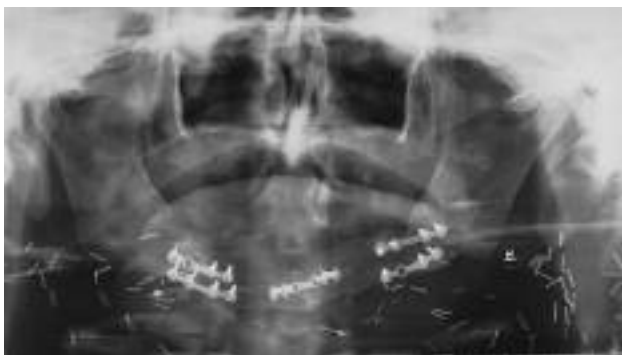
Orthopantomogram (1 year after surgery).
